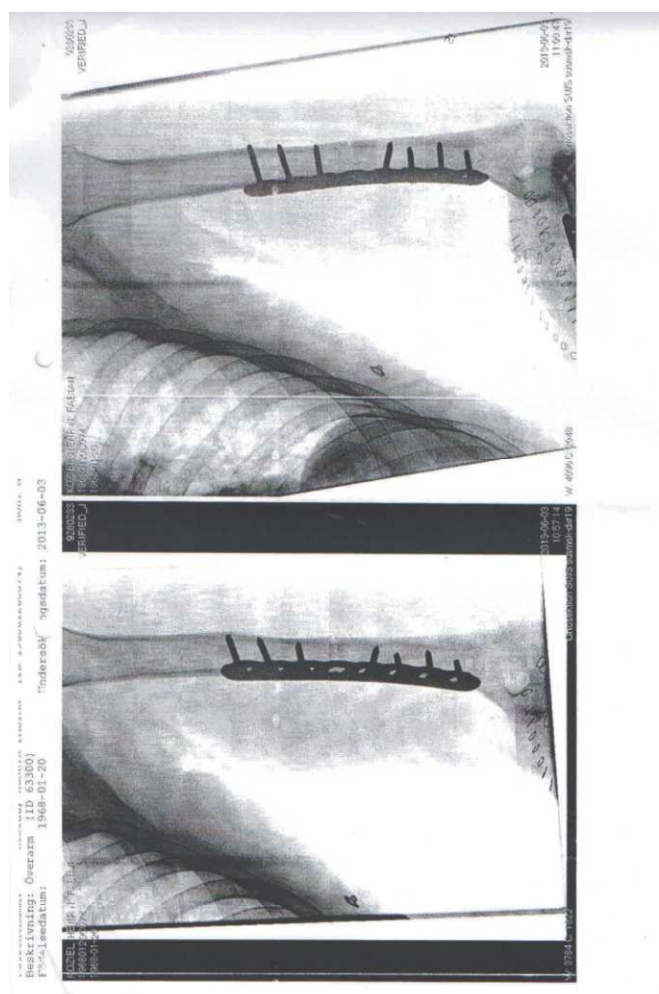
Postoperative radiographs of the arm
